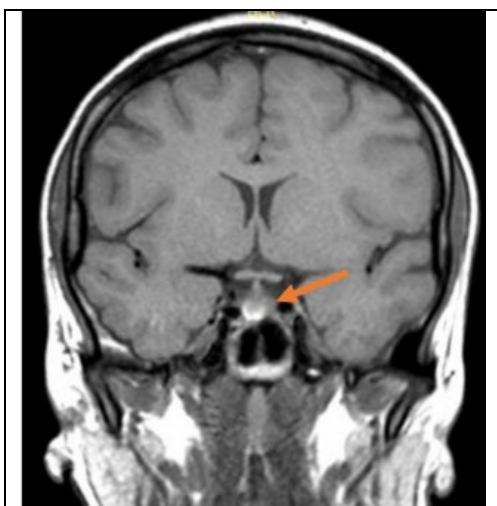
Coronal section of the MRI brain showing a pituitary microadenoma just above the Sella turcica
